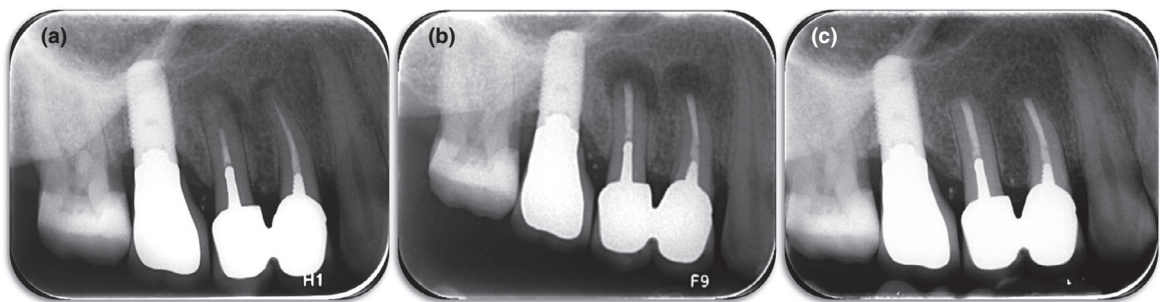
Teeth No. 14 and 15—Retrograde root canal retreatments. (a) Preoperative radiograph. (b) Postoperative radiograph demonstrating minimal resections and retrograde preparations and fillings to a depth of 7 and 8 mm in teeth No. 14 and 15, respectively. (c) One-year follow-up showing complete healing.
